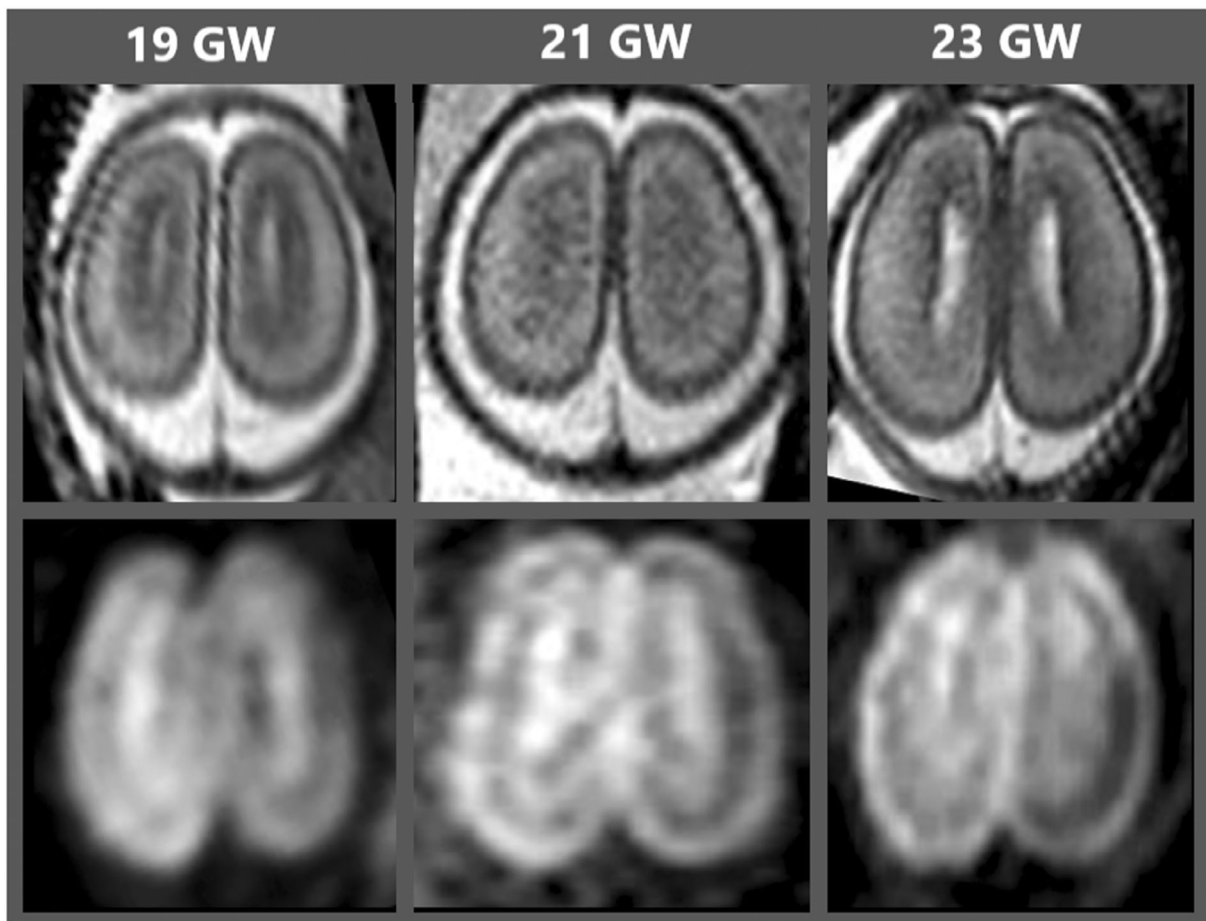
Normal cerebral mantle layering on T2 and DWI (b = 700) at different gestational ages (19, 21, and 23 GW). Upper row: axial T2-weighted images reveal subplate as a hyperintense layer subjacent the cortical plate; layering is better seen at 19 GW and almost completely disappeared at 23 GW; lower row, diffusion-weighted images show persistent layering with visibility of the hypointense subplate well into the 23 GW
